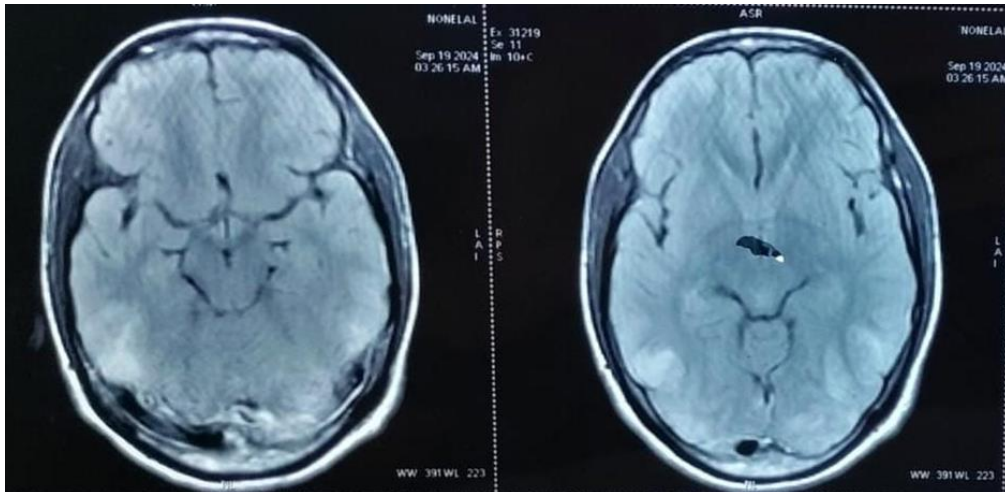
T2 FLAIR image showing hyper intensities over bilateral parieto-occipital region
